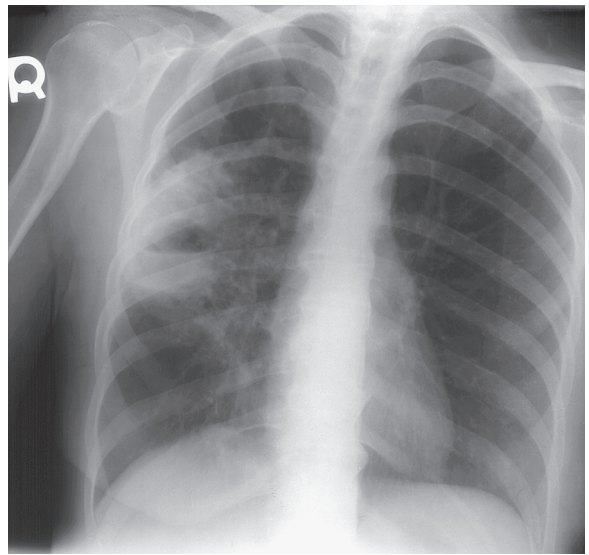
■ Posteroanterior chest radiograph demonstrating a lung abscess with air-fluid level.
